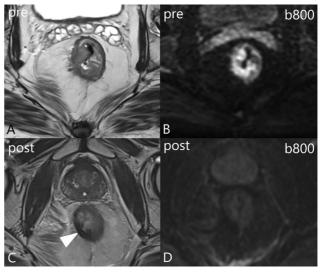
Split scar sign in magnetic resonance tumor regression grade (mrTRG) 1 or complete response (cCR). Baseline (A) axial T2 high-resolution (HR) magnetic resonance imaging (MRI) and (B) diffusion-weighted imaging (DWI) (b800) show a right posterior wall, semiannular, intermediate signal intensity, diffusion restricting cT3b, N0 low rectal cancer. (C) Post-long-course chemoradiotherapy (LCRT), axial T2 HR MRI shows tram track-like T2 hypointense signal along the mucosa and muscularis with intervening intermediate signal submucosa (positive split scar sign, arrowhead). (D) Post-LCRT, DWI (b800) shows no diffusion restriction.
